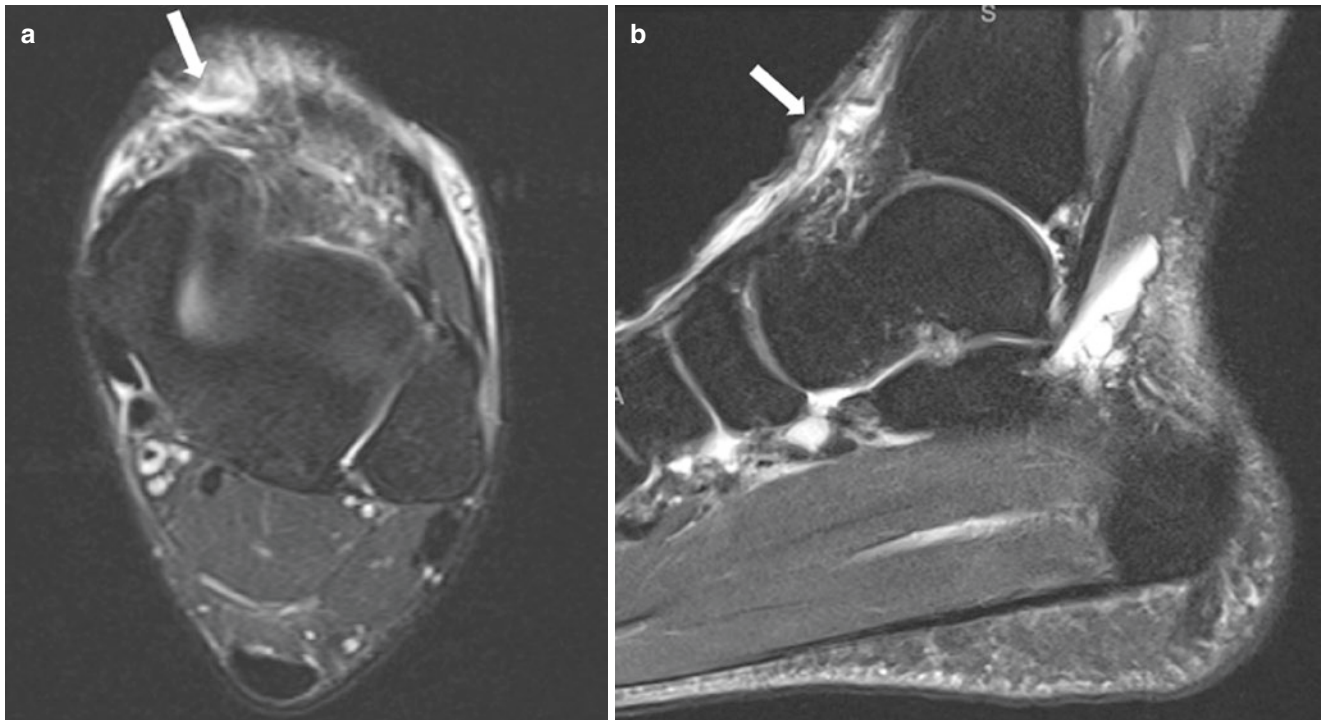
Anterior tibialis tendon tear. Axial (a) and sagittal (b) fat-suppressed T2-weighted MR images of the right ankle demonstrate a full-thickness tear of the anterior tibialis tendon (arrows) secondary to a recent laceration injury
